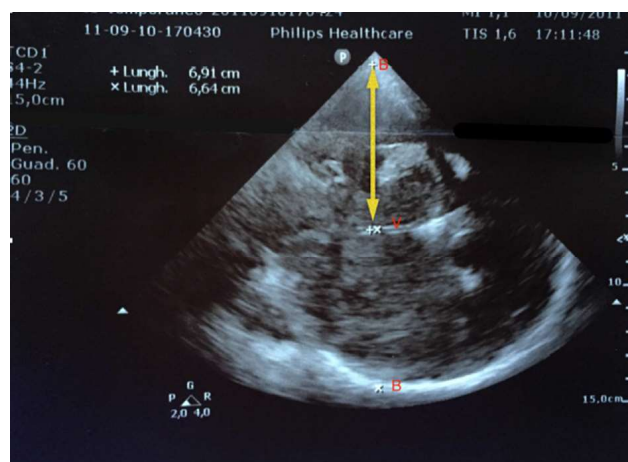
Midline shift (MLS) measurement by using ultrasound. B: ipsilateral and contralateral bone tables; V: the third ventricle, identified as a double hyperechogenic image over the midbrain. The distance between the external bone table and the center of the third ventricle is then measured bilaterally (yellow arrow). $MLS = (B1V-B2V)/2$
